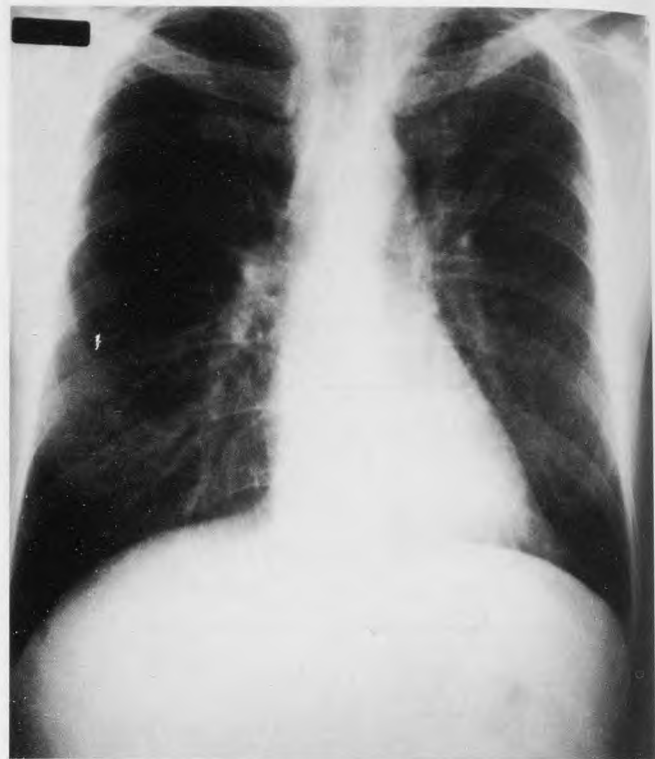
Chest radiograph of patient infected with HIV 5 months after initial evaluation and follow-up treatment. There is clearing of the interstitial process and pleural effusion. Continued patchy consolidation in the upper lobe of the left lung is present.
